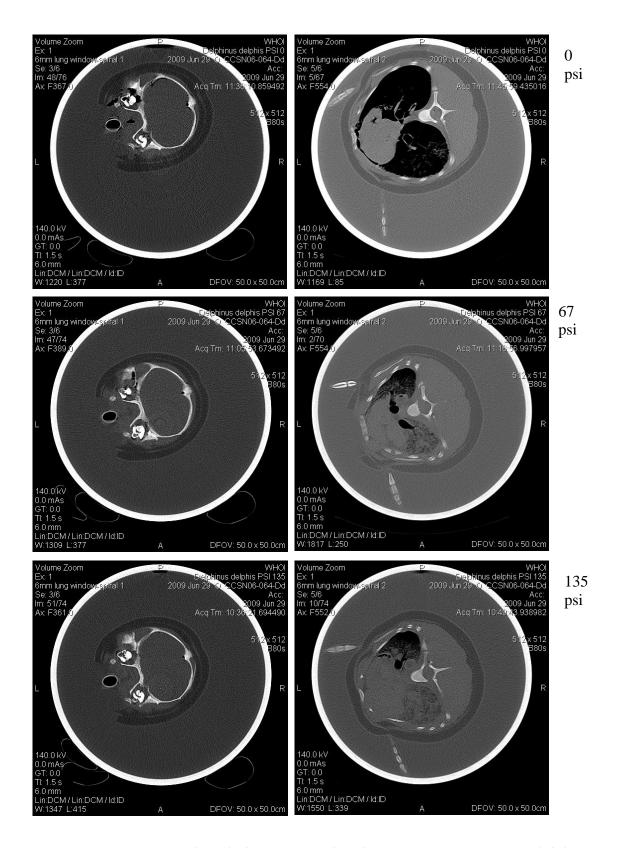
CT sections though the pressure chamber containing a common dolphin. Note lung compression (shrinking dark areas on right panel), whereas trachea remains the same size (dark circle on left series). Note also loss of buoyancy with increasing pressure.
